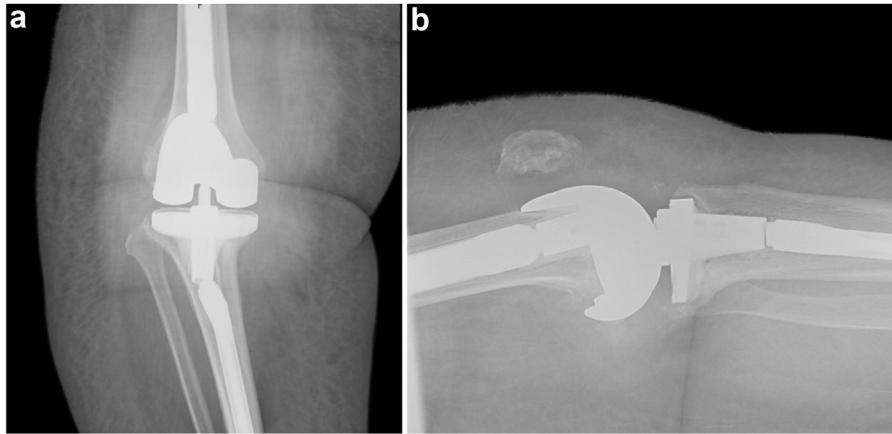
Anteroposterior (a) and lateral (b) right knee radiographs demonstrating tibial component loosening and mechanical failure with breakage at the tibial stem junction.
